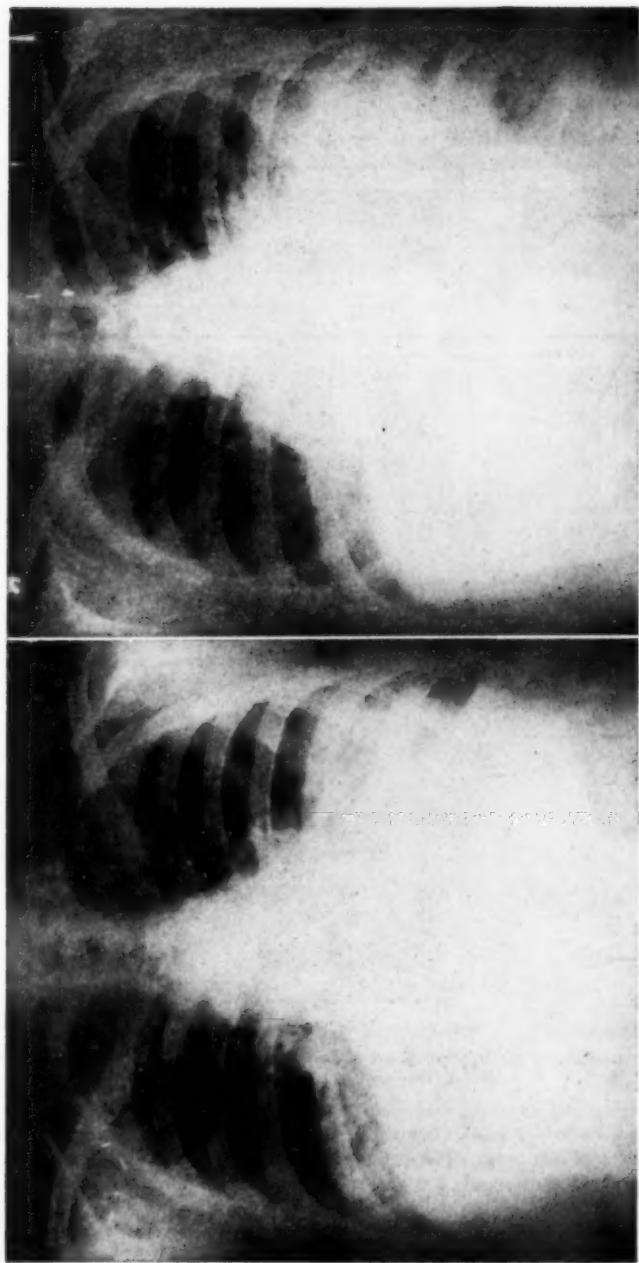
Roentgenogram of the chest taken in October, 1951. Note peribronchial thickening of both bases.
